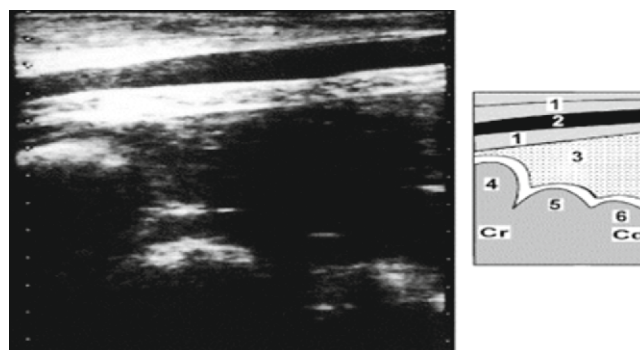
Ultrasound exam of the normal reticulum, craniodorsal blind sac of the rumen, ventral sac of the rumen, and abomasum viewed from the left ventral thorax: (1) ventral abdominal wall, (2) musculophrenic vein, (3) abomasum, (4) reticulum, (5) craniodorsal blind sac of the rumen, (6) cranial part of the ventral sac of the rumen (Braun, 2003).
